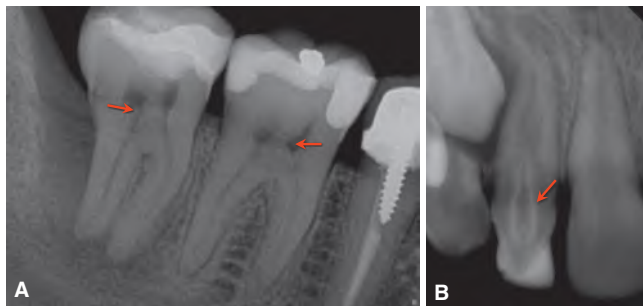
A. Identification of *pulpal calcification* (red arrows), or stones, in mandibular molars. B. Presence of a *dens invaginatus* (red arrow) can only be made with knowledge of normal tooth and pulpal anatomy as viewed on radiographs. Teeth affected by this developmental anomaly can present endodontic treatment challenges. (Courtesy of Dr. Reham Sharroufna, Los Angeles, CA. (Figure 10-17A) and Dr. Carl M. Allen, Columbus, OH. (Figure 10-17B).)
